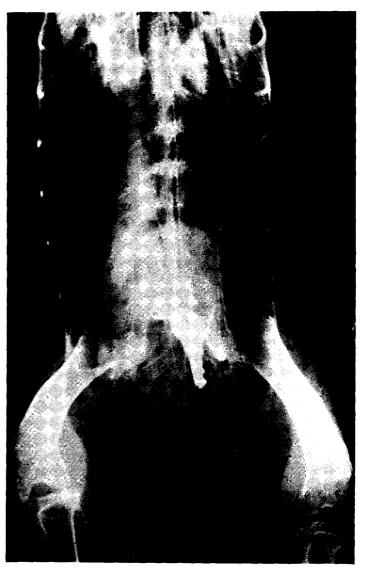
Ventrodorsal radiograph of crane 3, showing 2 wires and a key within the gizzard.
